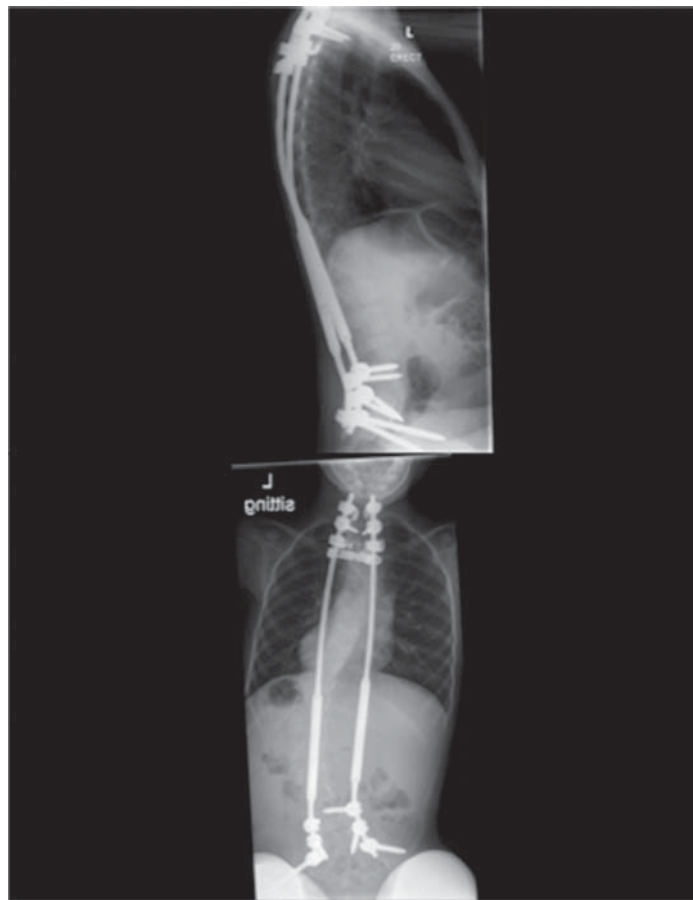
AP and lateral radiographs after first distraction—3 months. AP indicates anteroposterior.
